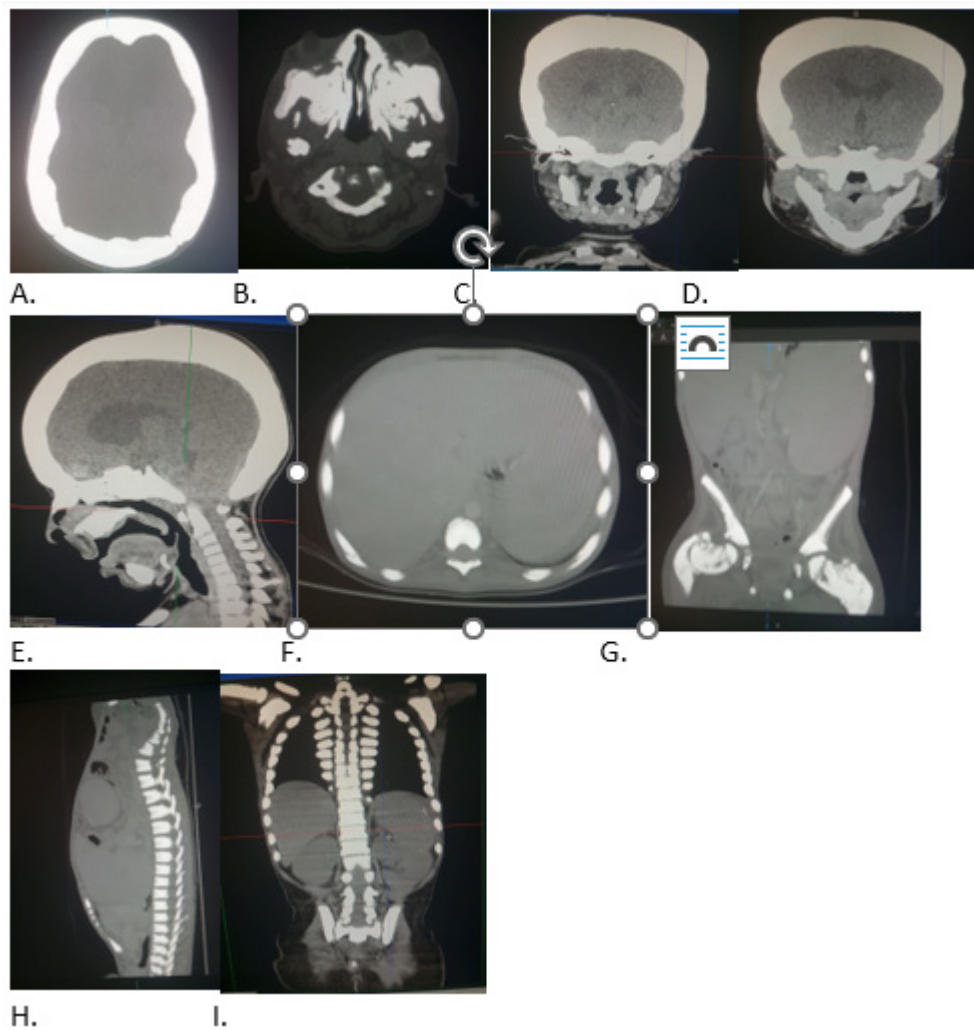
Radiological impression on the basis of CT scan.
